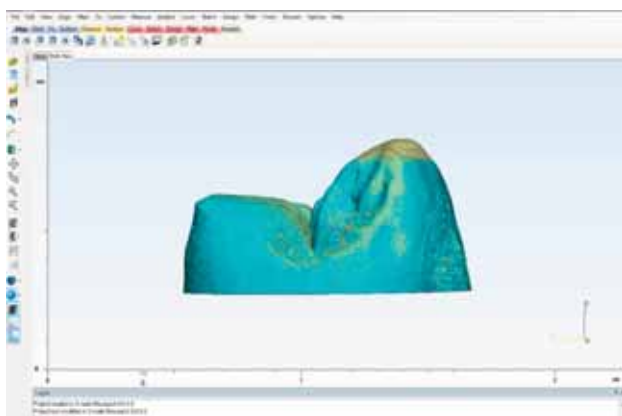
Matching and overlapping of the two μ CT-scanned tooth crown 3D images (before and after the wear cycles) using 3-matic software.
